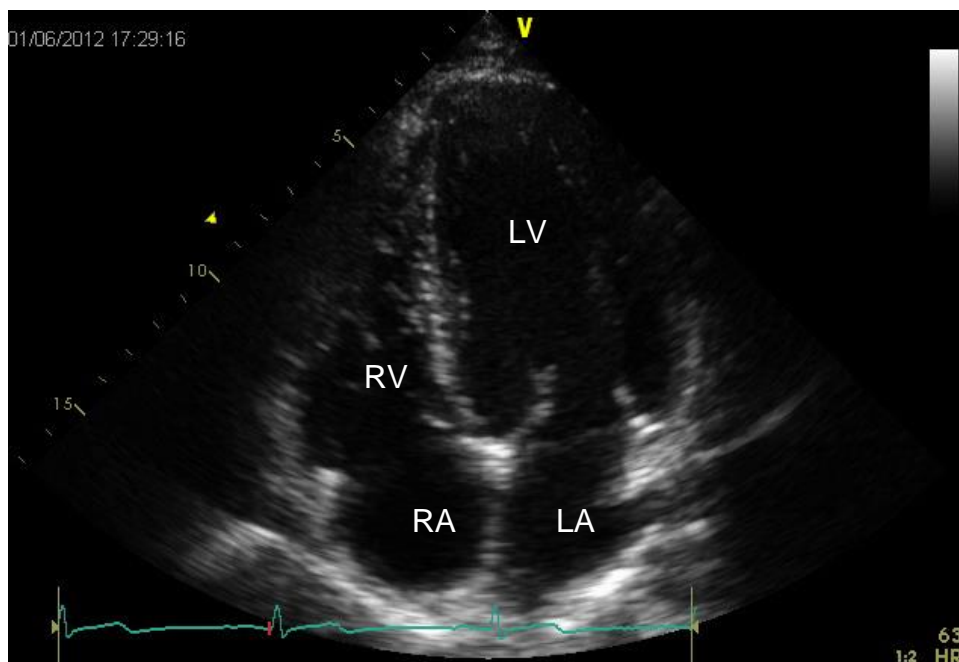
Apical four chamber view taken from the apical window that lies in a more lateral position
